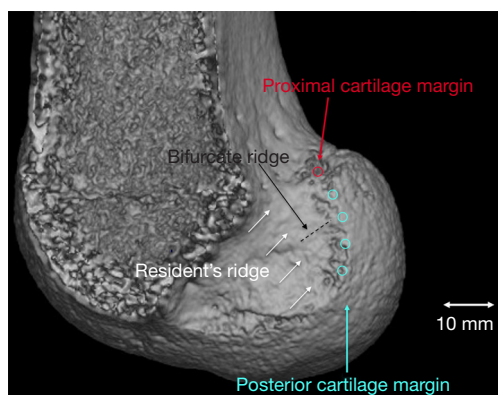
ACL femoral attachment area of the right knee shown on 3D CT. There are three landmarks to identify the area: the resident's ridge, proximal cartilage margin, posterior cartilage margin. ACL, anterior cruciate ligament.
